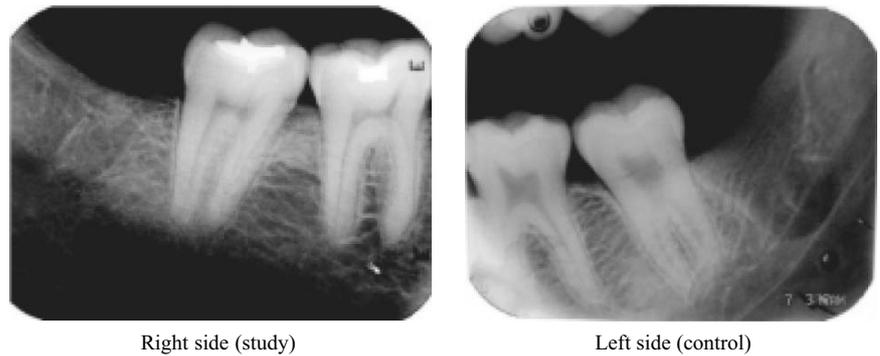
Radiograph (IOPA) at 8 weeks postoperatively
